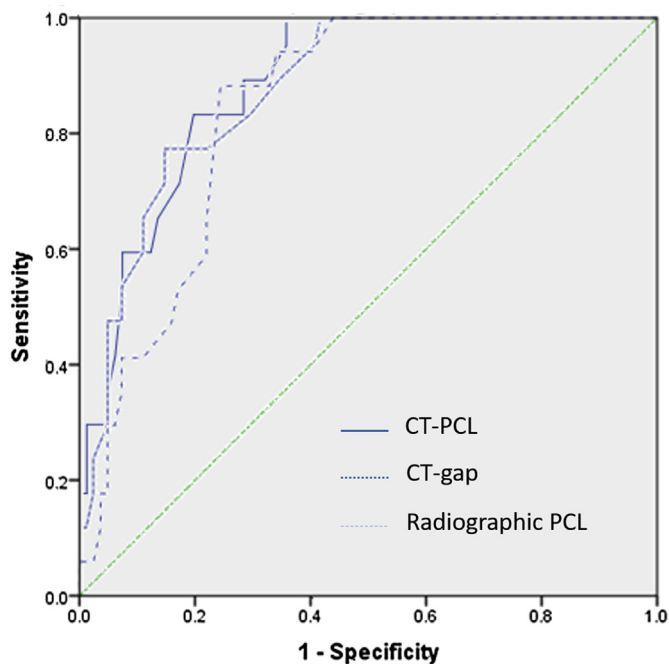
Receiver-operating characteristic curve analysis of CT-PCL, CT-gap, and radiographic PCL revealed respective areas under the curve of 0.89, 0.88, and 0.84, respectively. AUC, area under the curve; CT, computed tomography; PCL, plate-to-critical line distance.
